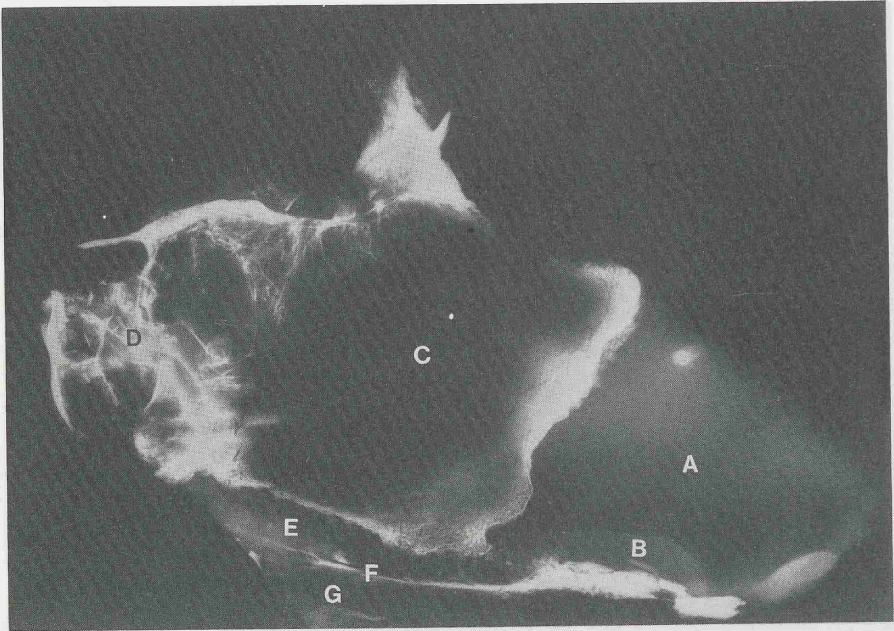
Lateral X-ray picture of nasal septum, age 30 years.
